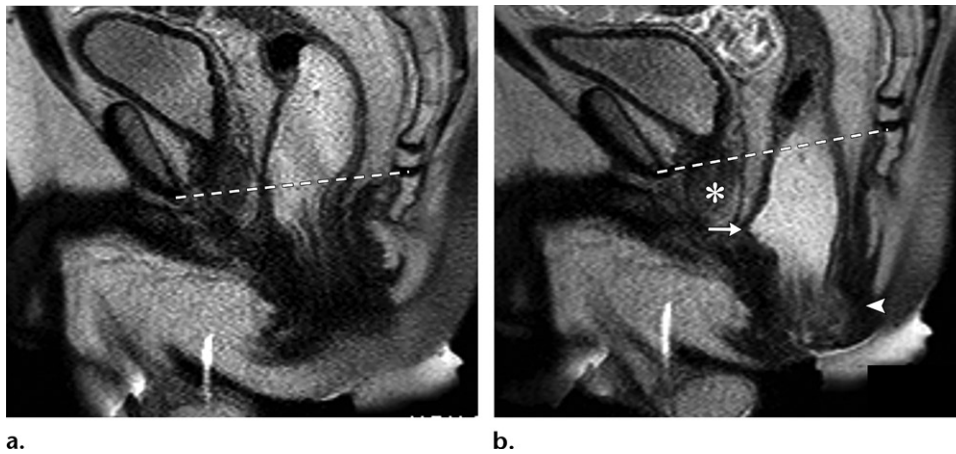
Anorectal descent and rectocele in a 50-year-old man with AIDS who was treated with rectopexy 6 months earlier and returned for evaluation after hearing a “pop.” Sagittal T2-weighted MR images acquired with the patient at rest (a) and while straining (b) show anorectal descent (arrowhead in b) and a small anterior rectocele (arrow in b) measuring approximately 1.1 cm. Note the descent of the prostate (* in b) below the pubococcygeal line (dashed line in a and b) (Movie E3).
